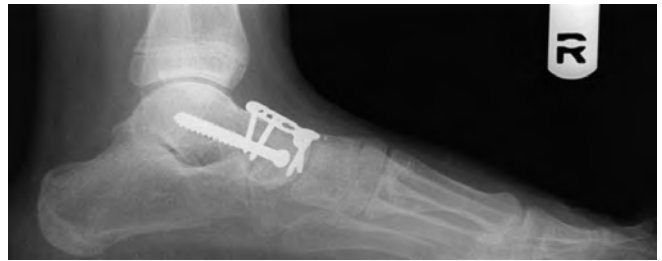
TH 8 month postoperative lateral radiograph. Note the inclination angle of the calcaneus as well as the talar-first metatarsal angle.
